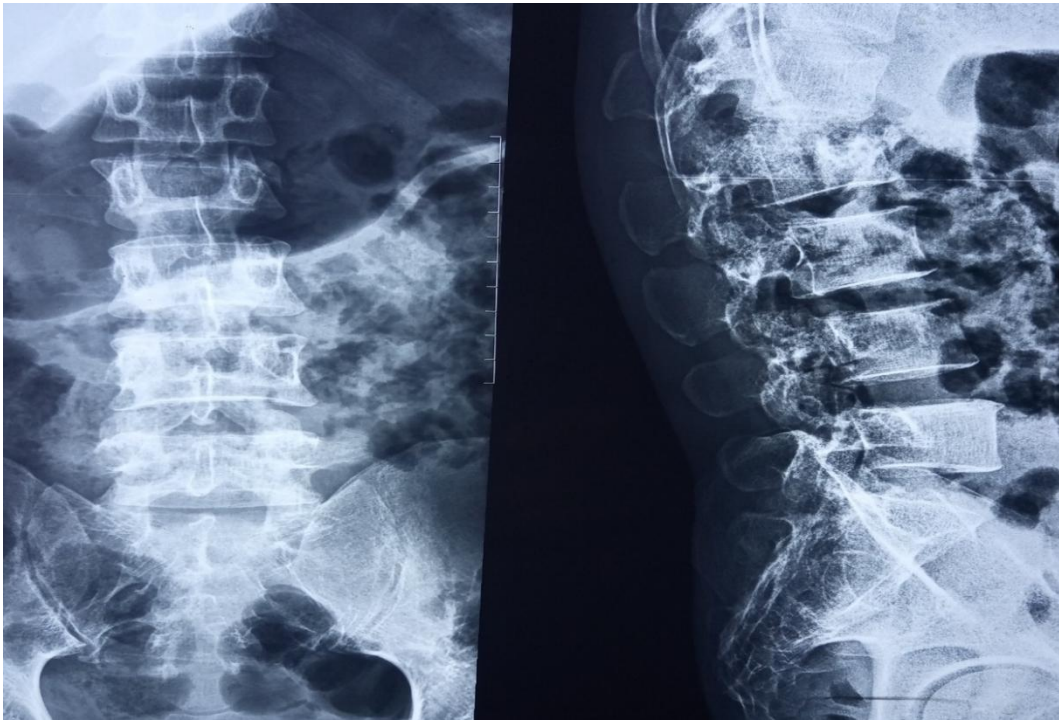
Plain radiograph of compression fracture of second lumbar vertebra (anterior wedge) in a 41-year-old male from a falling sliding gate
